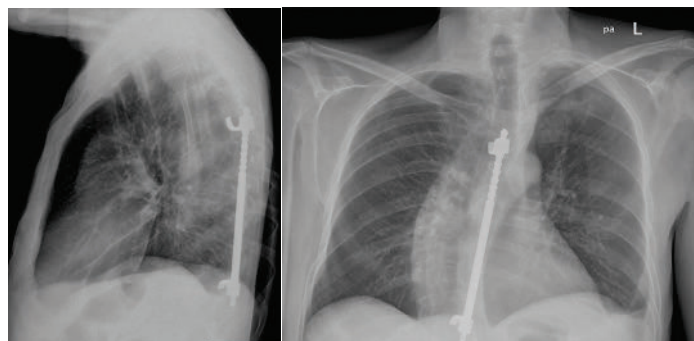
Anteroposterior (a) and lateral (b) x-ray views of Harrington rod system in the thoracic spine. Image source: chestdevices.com.
